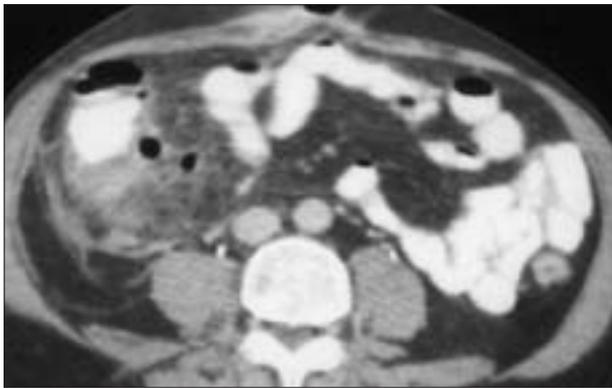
On axial CT image, an area of ill-defined and variable enhancement with pockets of extraluminal gas is present due to an appendiceal abscess. Note that there is thickening of the peri-cecal fascia.
